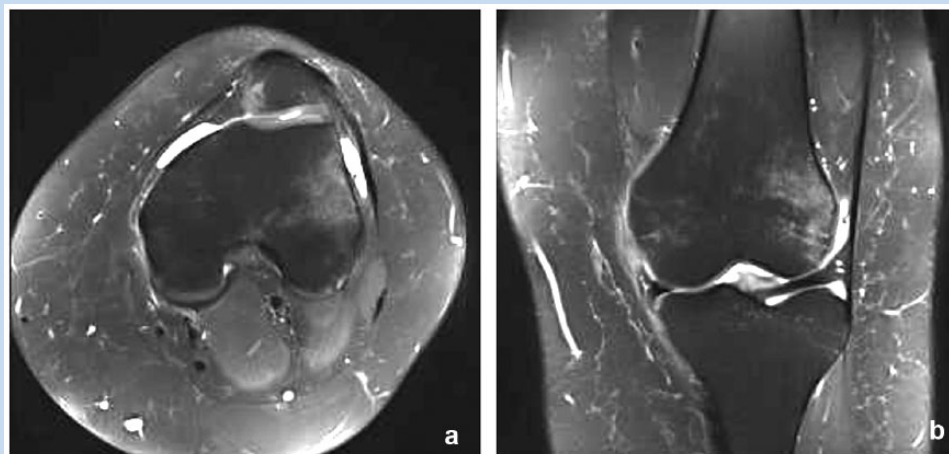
Acute lateral patellar dislocation. Magnetic resonance images (MRIs) demonstrating the bony edema pattern on the inferomedial patella and lateral aspect of the lateral femoral condyle. (a) T2-weighted axial MRI. (b) T2-weighted coronal MRI.
